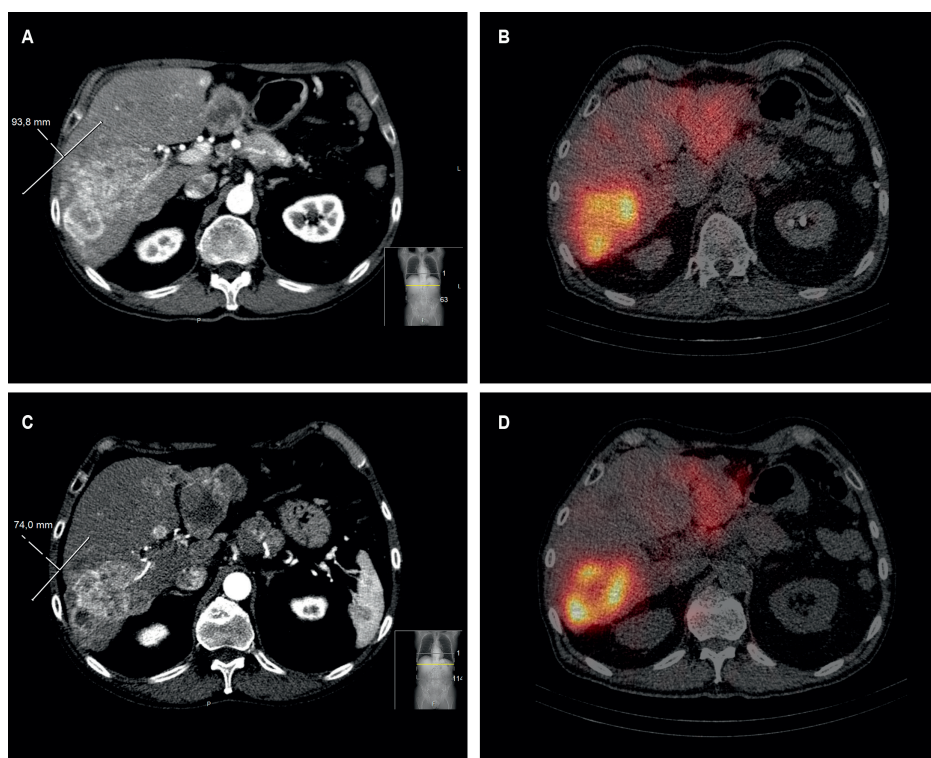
Example case. A 65-year-old male with neuroendocrine tumor metastases was treated with one-day ^{166}Ho -radioembolization. Figure a shows the baseline contrast-enhanced CT image with a large hypervascular metastasis in segment 6. Figure b shows the distribution of ^{166}Ho -scout on SPECT/CT. Figure c shows the contrast-enhanced CT image 3 months after treatment, with evident shrinkage (see annotation) of the metastasis in segment 6. Figure d shows the distribution of the ^{166}Ho -treatment dose on SPECT/CT.
